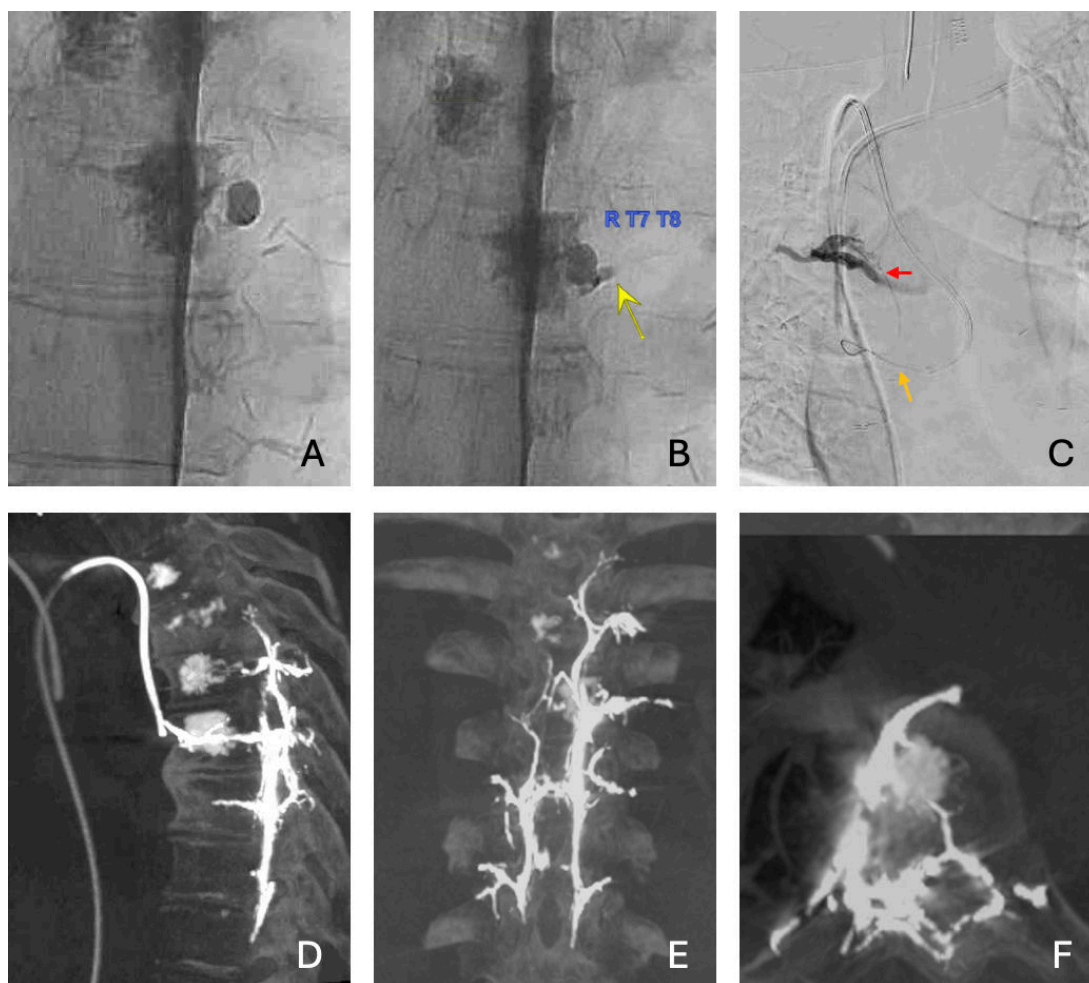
(A) Lateral decubitus right-sided digital subtraction dynamic myelography demonstrating a T7 foraminial dural cyst. (B) A cerebrospinal fluid-venous fistula originating from the cyst (yellow arrow). (C) Transvenous embolization of the fistula via catheterization of the azygos vein. The right T7 segmental vein (red arrow) was accessed using a 156 cm Headaway Duo catheter navigated through the epidural plexus (orange arrow) from the T8 segmental vein. (D)–(F) Post-embolization cone-beam CT images in sagittal (D), coronal (E), and axial (F) reconstructions showing successful embolization with Onyx.
